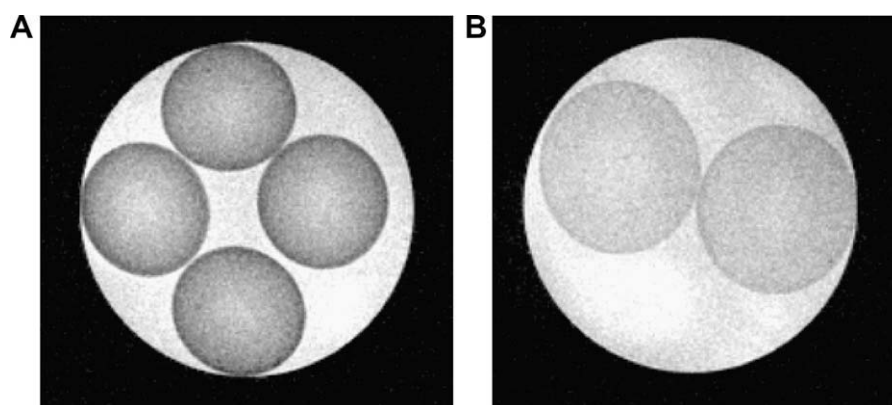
MR images of strong (A) and weak (B) alginate gel beads at 7 T ($TE = 40$ ms) in calcium chloride and sodium chloride solution, respectively.
